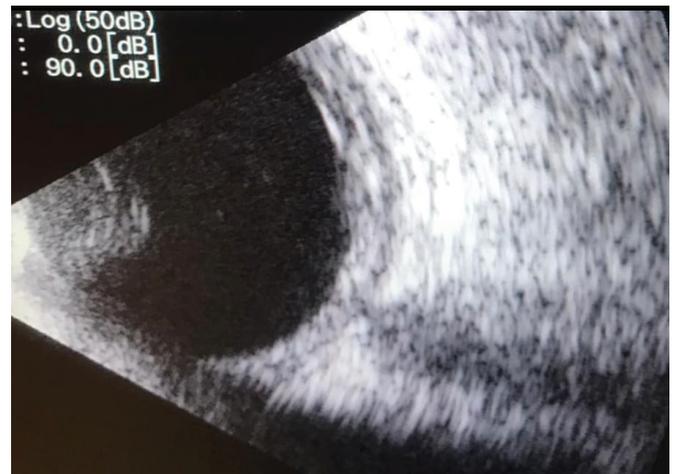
Diffuse scleral thickening in B-scan ultrasonography at first visit.
